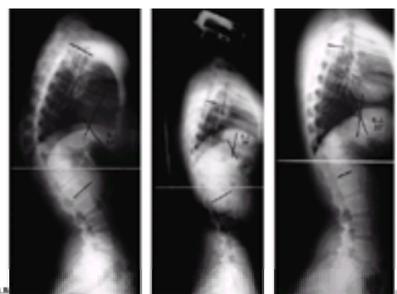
A: A 15-year-old girl with a 64-degree thoracic kyphosis secondary to Scheuermann disease. B: Lateral radiograph of the patient in a Milwaukee brace with the kyphotic deformity improved to 39 degrees. C: Lateral radiograph obtained after the patient completed brace treatment; the kyphotic deformity has improved to 33 degrees.
